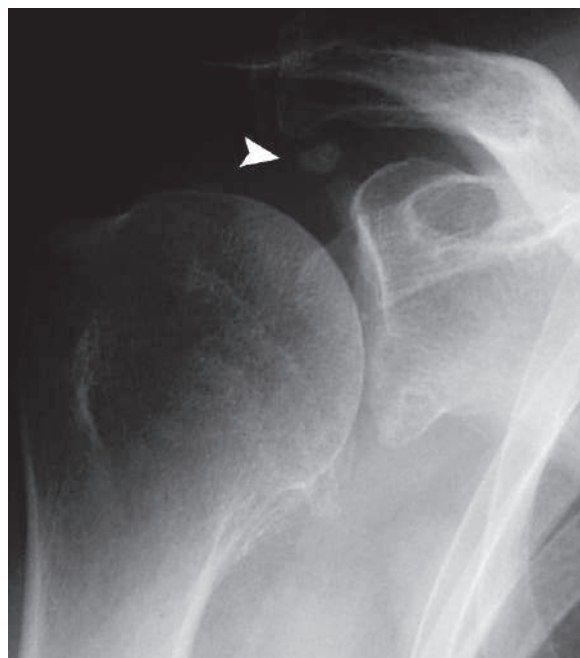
Plain radiograph of the shoulder shows calcification in the area of the supraspinatus tendon due to HADD (*arrowhead*)
